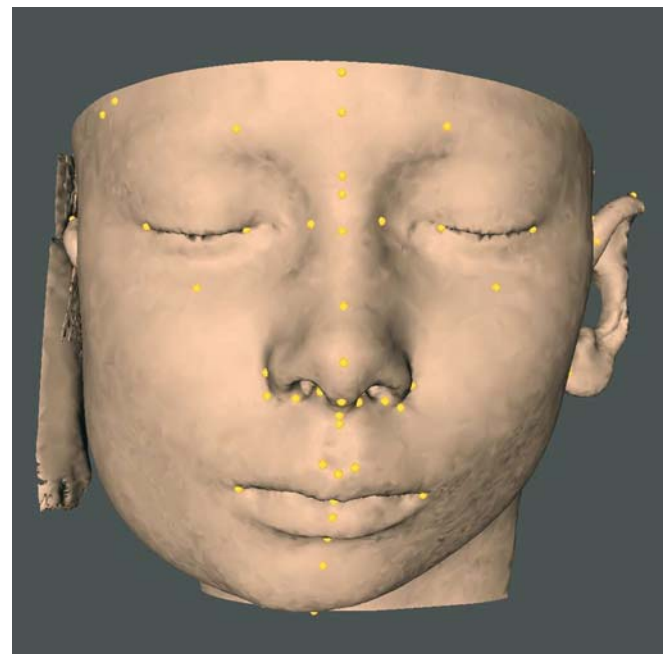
Post-distraction 3-D CT soft tissue surface representation with set-up of 3-D cephalometric soft tissue landmarks. Frontal view. Note artefacts at the level of the right ear (3-D CT, patient B.R.)
